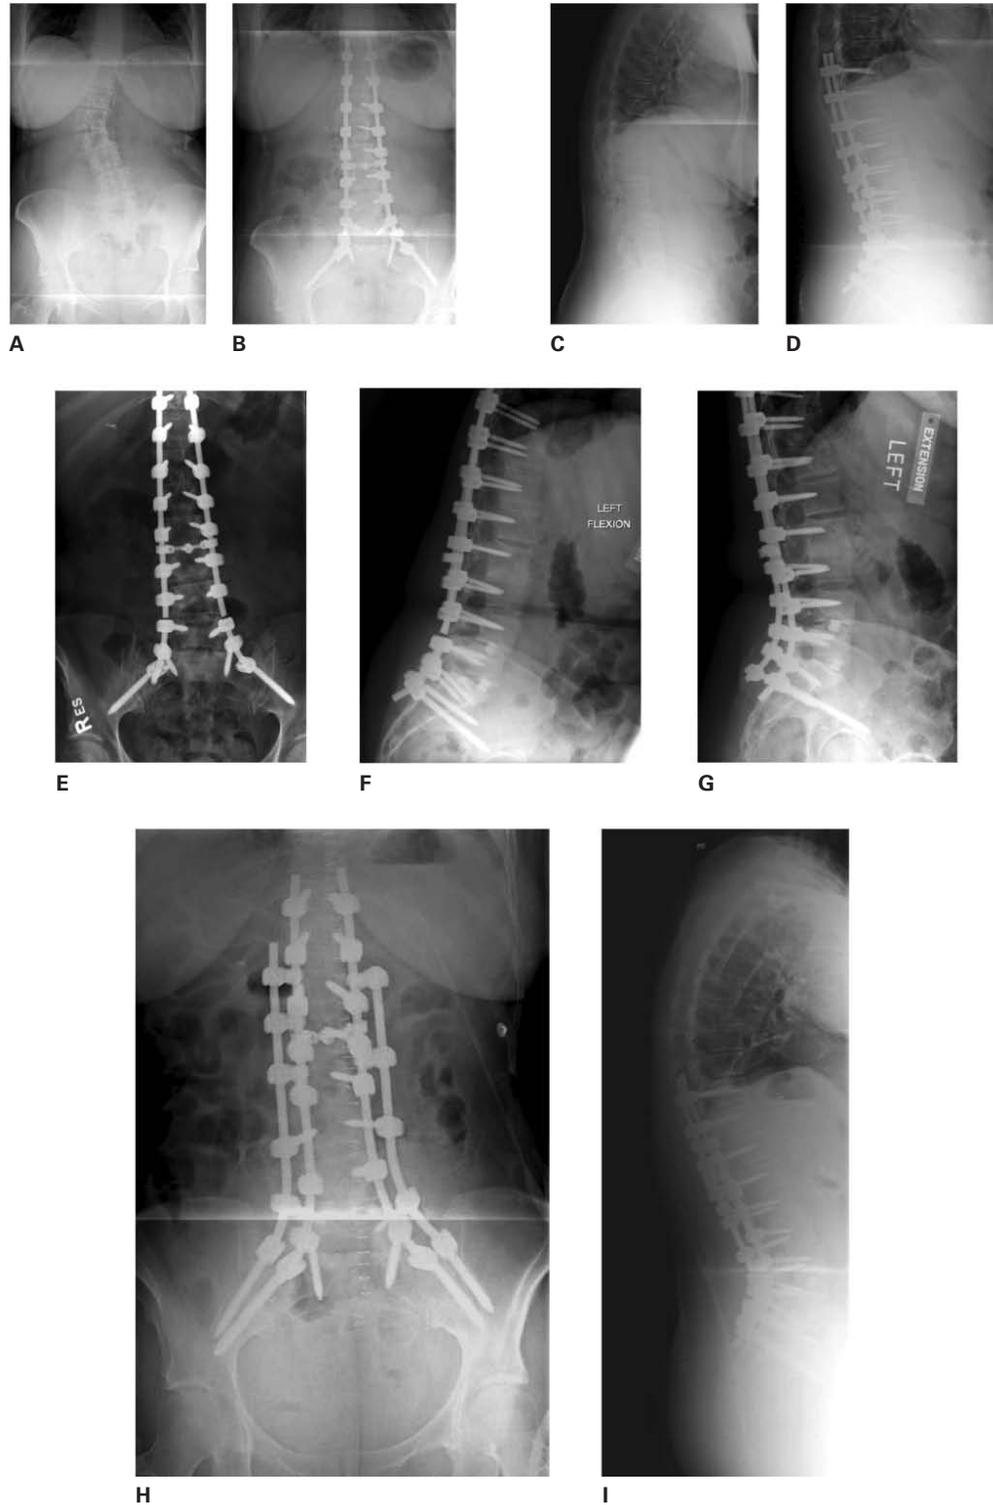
Case Example: preoperative (A,C) and immediate postoperative (B,D) standing radiographs of a 56 year-old female who underwent posterior instrumented fusion from T10 to the pelvis with transforaminal lumbar interbody fusion at L4-5 and L5-S1 for correction of thoracolumbar degenerative kyphoscoliosis. At five months postoperatively, the patient complained of recurrent pain and deformity, and fracture of the bilateral 6.3mm titanium rods was noted (E,F,G). The patient subsequently underwent revision instrumentation from T10 to the pelvis with use of a four-rod construct (H,I).
